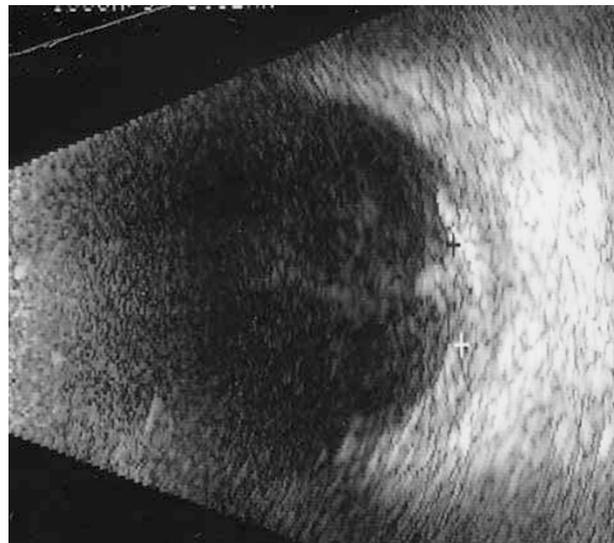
RE VPRT on B scan ultrasonography showing tumour diameter of 5.0 and 1.7 mm thickness.
